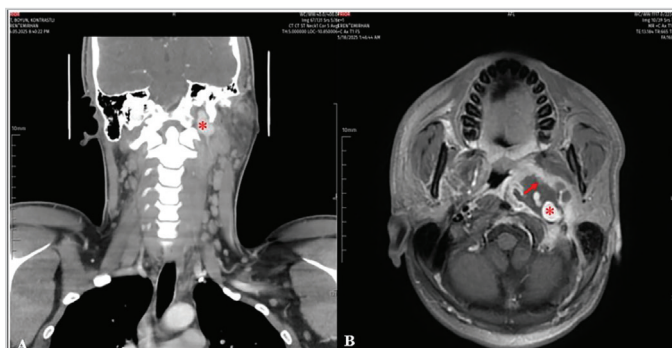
Pre-embolization images. A. Coronal contrast-enhanced CT showing a left parapharyngeal abscess and adjacent internal carotid artery pseudoaneurysm (asterisk), B. Axial contrast-enhanced T1-weighted MRI showing the pseudoaneurysm (asterisk) surrounded by hematoma (arrow)
